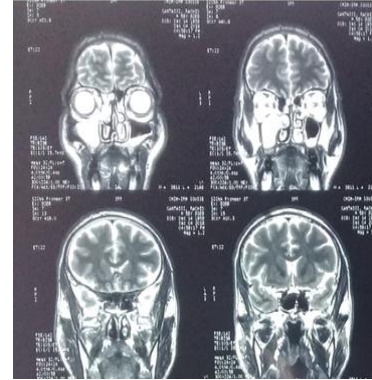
First cerebral MRI
